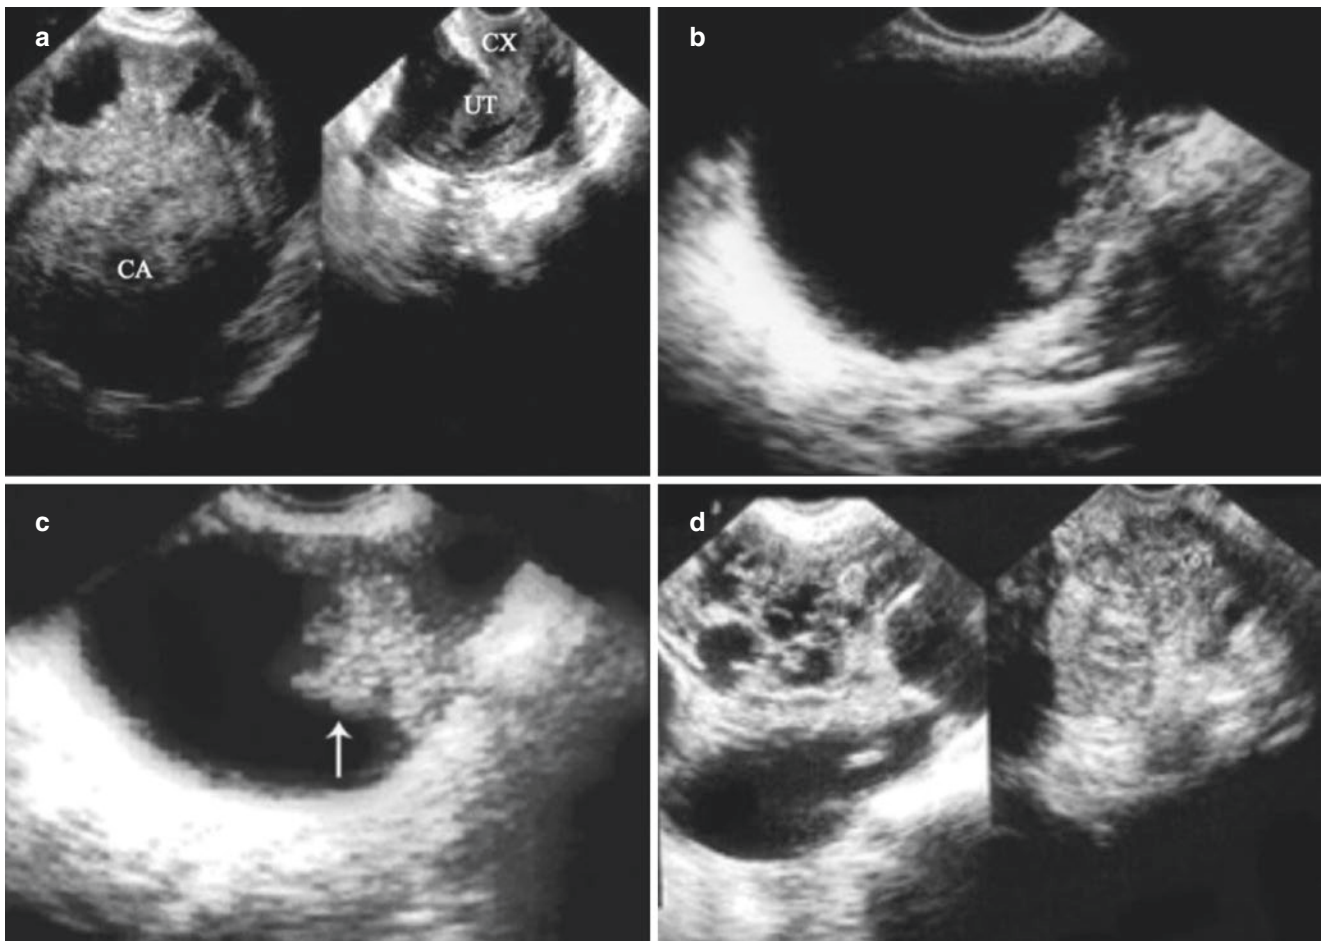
Ovarian malignant tumors (II). (a) A 68-year-old patient with a postmenopausal period of 18 years. The ultrasonic images show an atrophic uterus. A cystic dominated mixed echogenic mass with a diameter of 10.0 cm is shown in the right adnexa area, accompanied by
